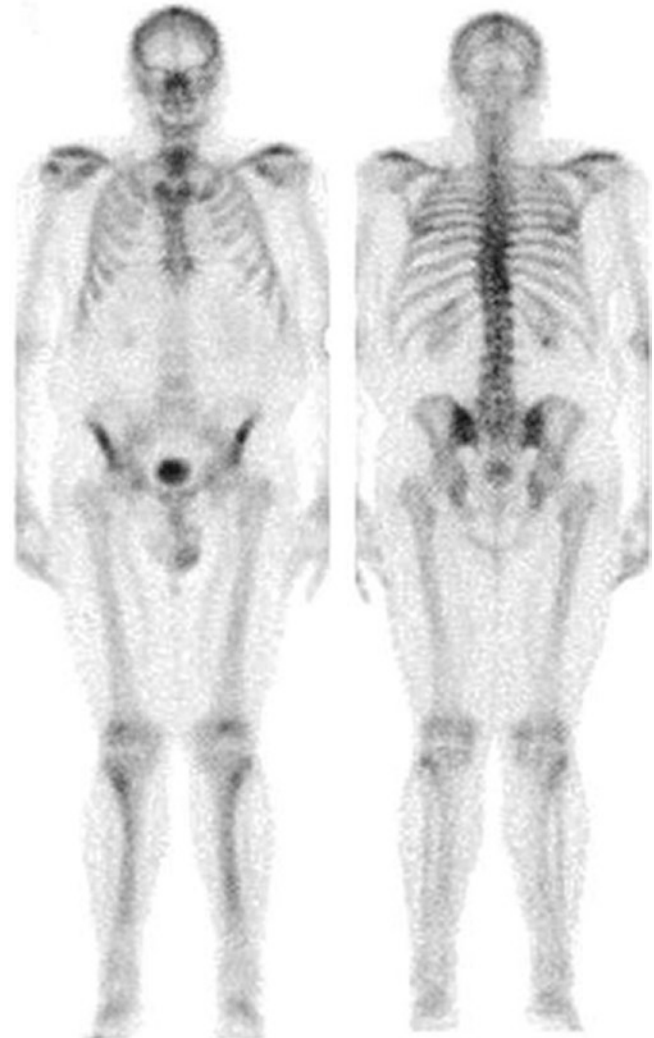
Standard images acquired for planar whole-body skeletal scintigraphy about 3 h after the i.v. administration of ^{99m}Tc -HDP. The left panel depicts the anterior and posterior views obtained in the whole-body imaging mode (with arms along the body). Tracer distribution throughout the skeleton only shows diffuse mild inhomogeneities (e.g., in lower portion of thoracic spine), with mildly increased uptake corresponding to the anterior arc of the second left rib. Furthermore, there is apparent focally increased tracer uptake at the posterior tract of the last ribs, due to overlapping of these bone segments with the kidneys, site of physiologic excretion. Radioactivity accumulation in the urinary bladder is clearly recognized (modified from: Volterrani D, Erba PA, Mariani G, Eds. *Fondamenti di Medicina Nucleare – Tecniche e Applicazioni*. Milan: Springer Italy; 2010)
